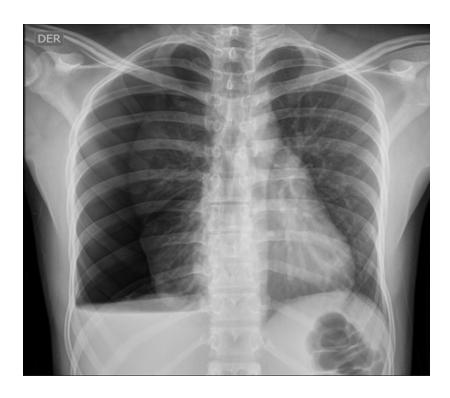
Chest X-ray with effacement of the costophrenic angle on the right side with the presence of an air-fluid level compatible with hydropneumothorax. Pneumothorax reaches a thickness of 7 cm at the lung base, 46 mm in the middle third of the lung field, and 50 mm in the apical region, with atelectatic changes significant in the right lung.
